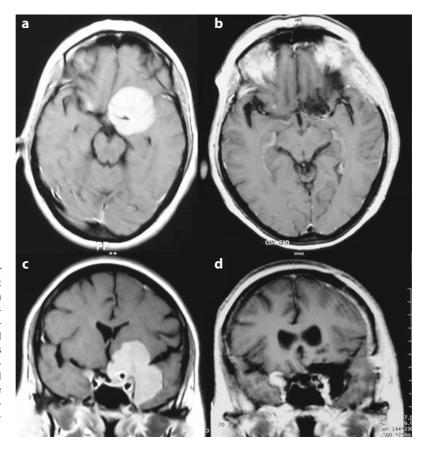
T1-weighted MR imaging after contrast agent administration of a giant left sphenocavernous meningioma with a small contralateral clinoidal meningioma. a, c Preoperative axial and coronal images. b, d Postoperative axial and coronal images. The meningioma was completely resected except for the intracavernous portion via a left pterional craniotomy. Residual tumor within the cavernous sinus and the contralateral clinoidal meningioma did not show progression at the 3-year follow-up
